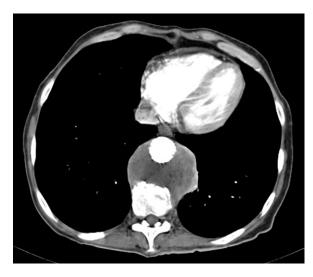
A computed tomography (CT) scan with contrast taken two months postoperatively when the patient returned to the hospital complaining of back pain. The lesion increased significantly in size since the last visit to a maximal diameter of 80 mm. Of note, there is no appreciable extravasation of contrast into the growing lesion.
